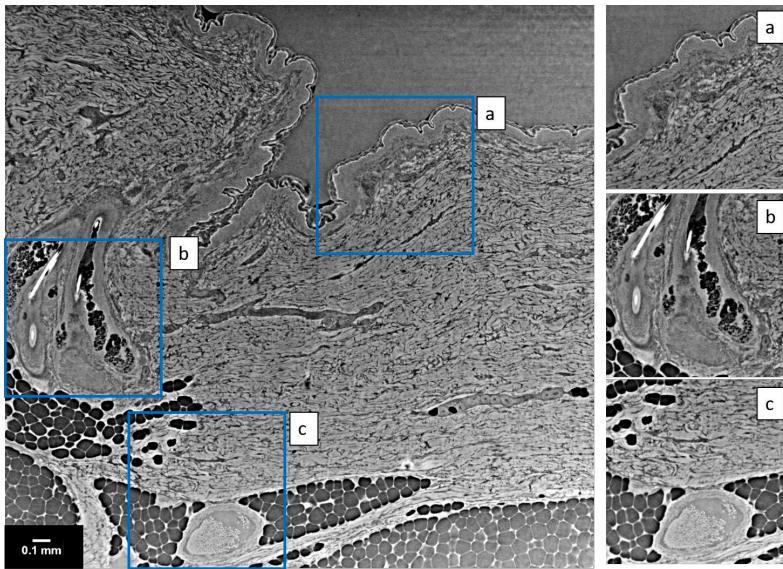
Skin tissue embedded in agar and considered for XPCT investigation at the SYRMEP beamline of the Elettra synchrotron. On the left, some zoomed details representing (a) a epidermal-dermal layer junction, (b) a pilosebaceous unit within dermis, and (c) hypodermal layer with a blood vessel. The experiment was conducted in parallel geometry, using the propagation-based setup with a polychromatic beam (average X-ray energy: $21\ \text{keV}$, pixel size: $2.0\ \mu\text{m}$, SDD: $20\ \text{cm}$).
